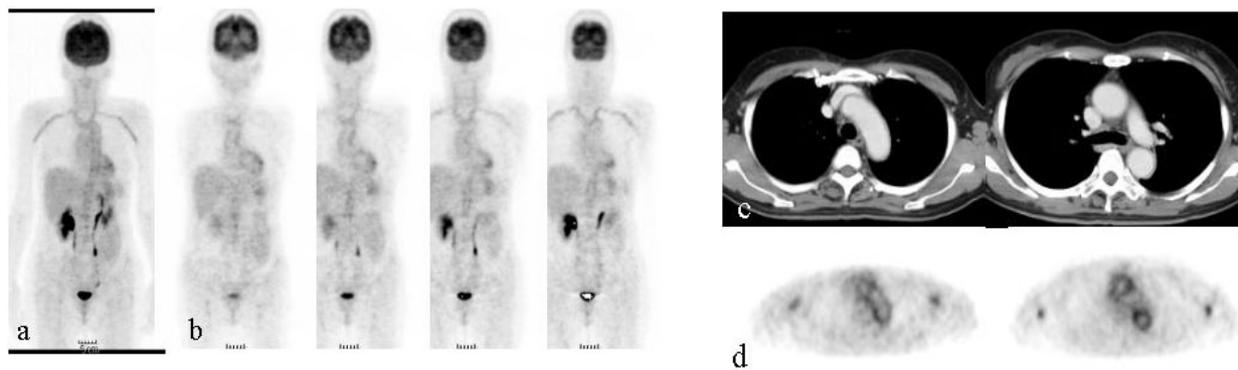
a, b: FDG-PET images show continuing uptake in the thoracic abdominal aorta, brachiocephalic artery, common carotid arteries, and subclavian arteries. (a, maximum intensity projection (MIP); b, coronal view.) c, d: CT images demonstrate aortic wall thickening (c). Intense abnormal FDG accumulation is noted in the aortic wall (d). (c, contrast-enhanced CT; d, FDG-PET axial views corresponding to the CT images.)
